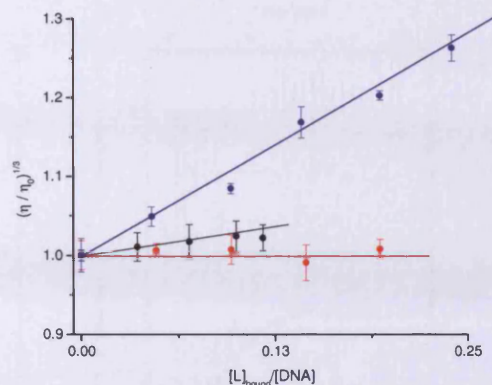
Relative viscosity of a 0.5 mM CT DNA solution upon addition of 5.1 (●), H33258 (●) and ethidium bromide (●) at 25 °C in 25 mM MOPS pH 7.0, 50 mM NaCl, 1mM EDTA.
